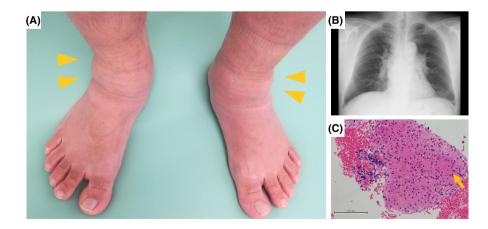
Bilateral swollen ankles with tenderness at the time of initial presentation (A). Chest radiograph shows bilateral hilar lymphadenopathy (BHL), which is suggestive of sarcoidosis (B). Needle biopsy from the BHL pathologically reveals nonnecrotizing epithelioid granulomas (arrow: Langhans giant cell) (C).
